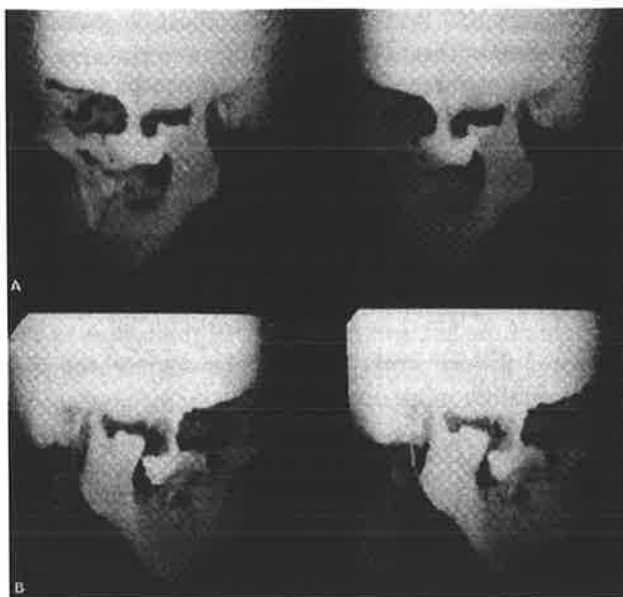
Near lateral a. left and b. right 3-D CT reconstructions showing in particular the severe hypoplastic nature of the patient's zygomas and absence of both zygomatic arches.
